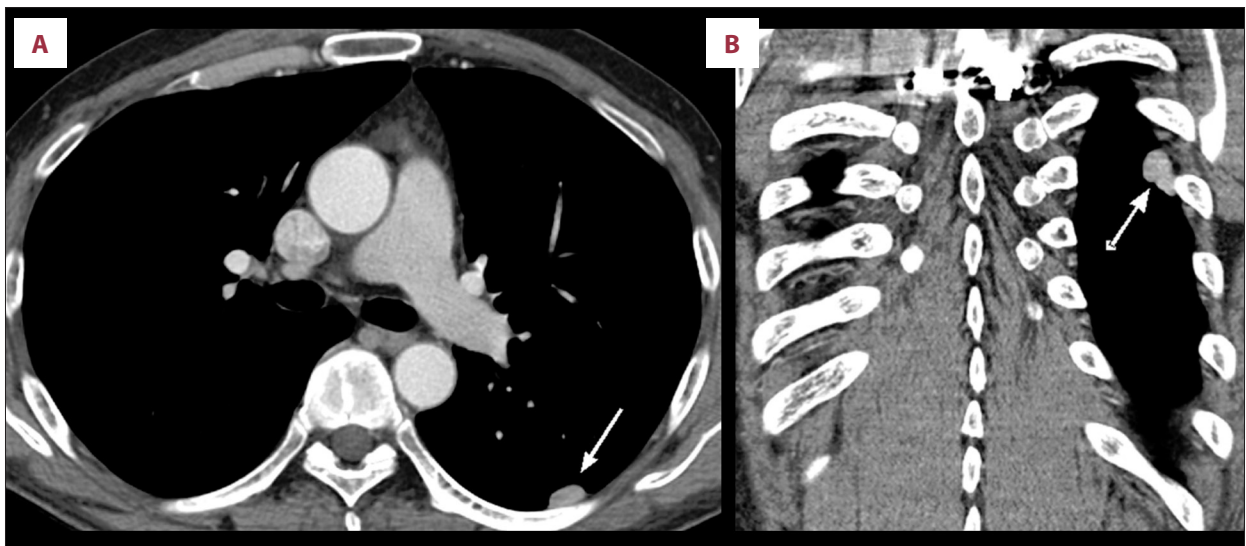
Coronal (A) and sagittal (B) chest CT revealing 1-cm focal pleural thickening in left pleura (arrows).
